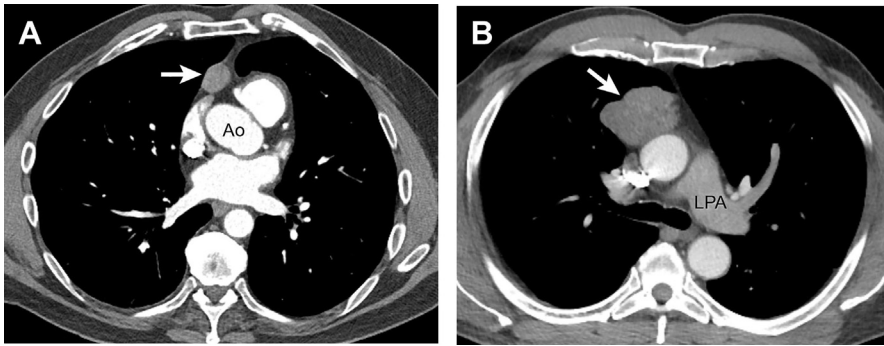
T1 tumors. (A) Contrast-enhanced axial CT of the chest at the level of the ascending aorta (Ao) shows a 3-cm oval mass in the right prevascular mediastinum (arrow) surrounded by fat. A thymoma with no capsular invasion was diagnosed at surgery, representing T1a disease. (B) Contrast-enhanced axial CT of the chest at the level of the left pulmonary artery (LPA) shows a 6-cm thymoma abutting the ascending aorta with a lobular contour with the lung (arrow). At surgery there was tumor invasion into perithymic adipose tissue and pleura only. Abutment of structures, such as the aorta or lung, does not necessarily translate to invasion.
